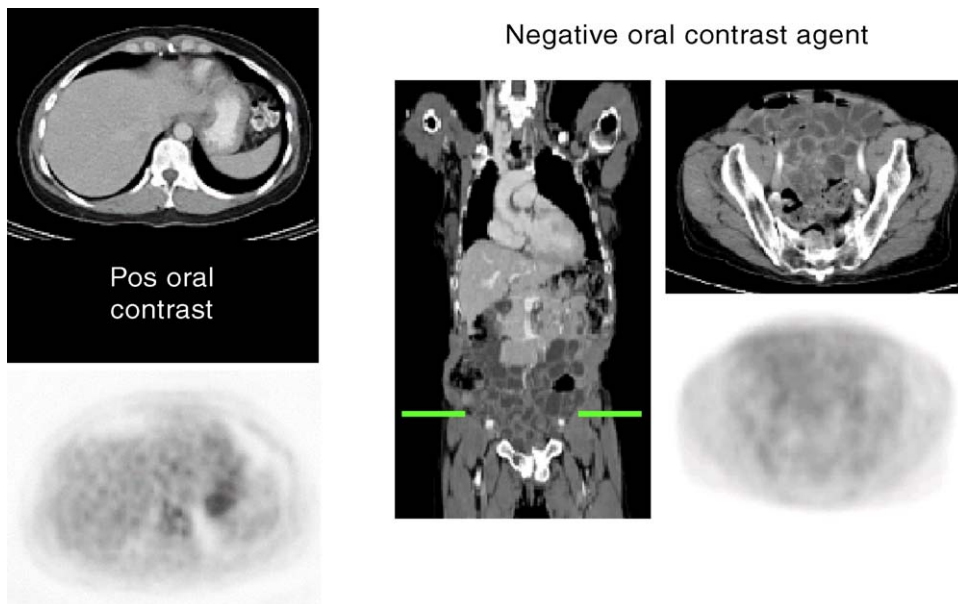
Positive oral contrast agents (left) may lead to high-density areas on CT (e.g., stomach, colon), which may further translate into artificial hot spots on corrected PET images. Using negative oral contrast agents (right) obviates the cause of these artifacts while providing good small bowel distention.⁹
